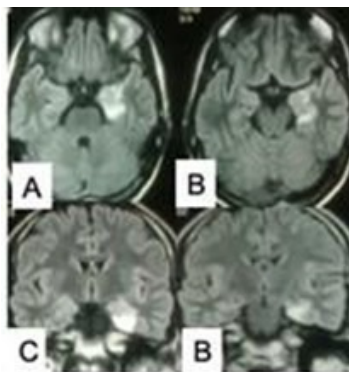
MRI of brain: (A,B) axial and (C,D) coronal views showing left amygdalo-hippocampal DNET causing TLE. Source: Figure by authors.
